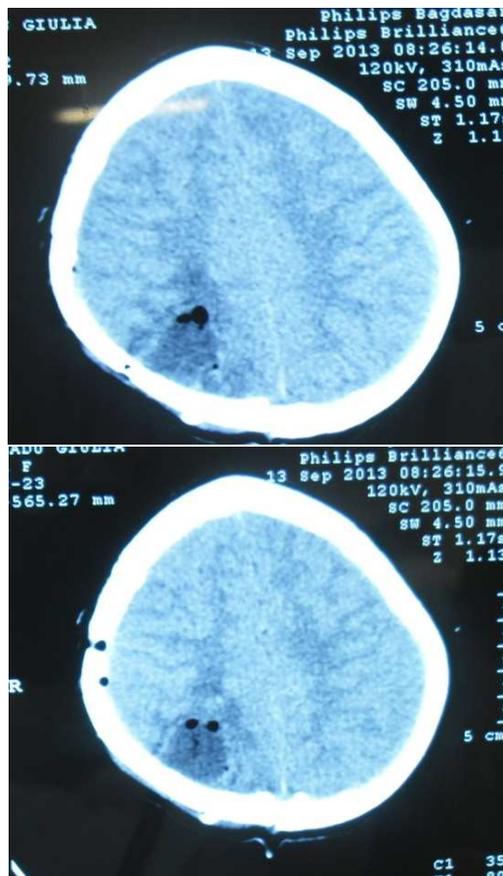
Postoperative control CT scan
